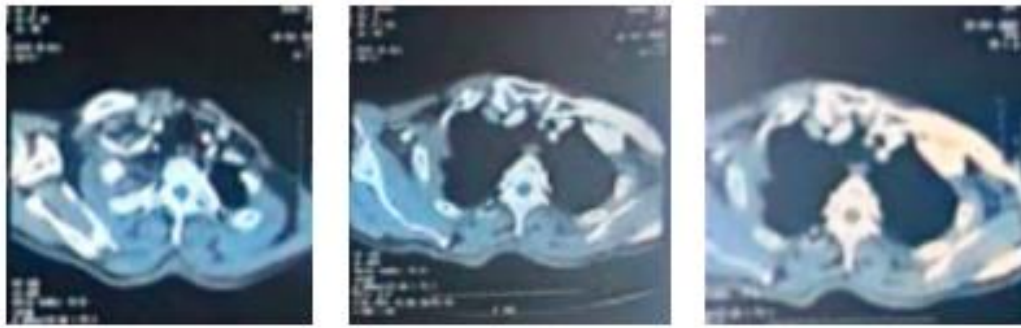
Cervicothoracic CT scan in axial section showing a parietal-pleural lytic process of the anterior arch of the first rib.
